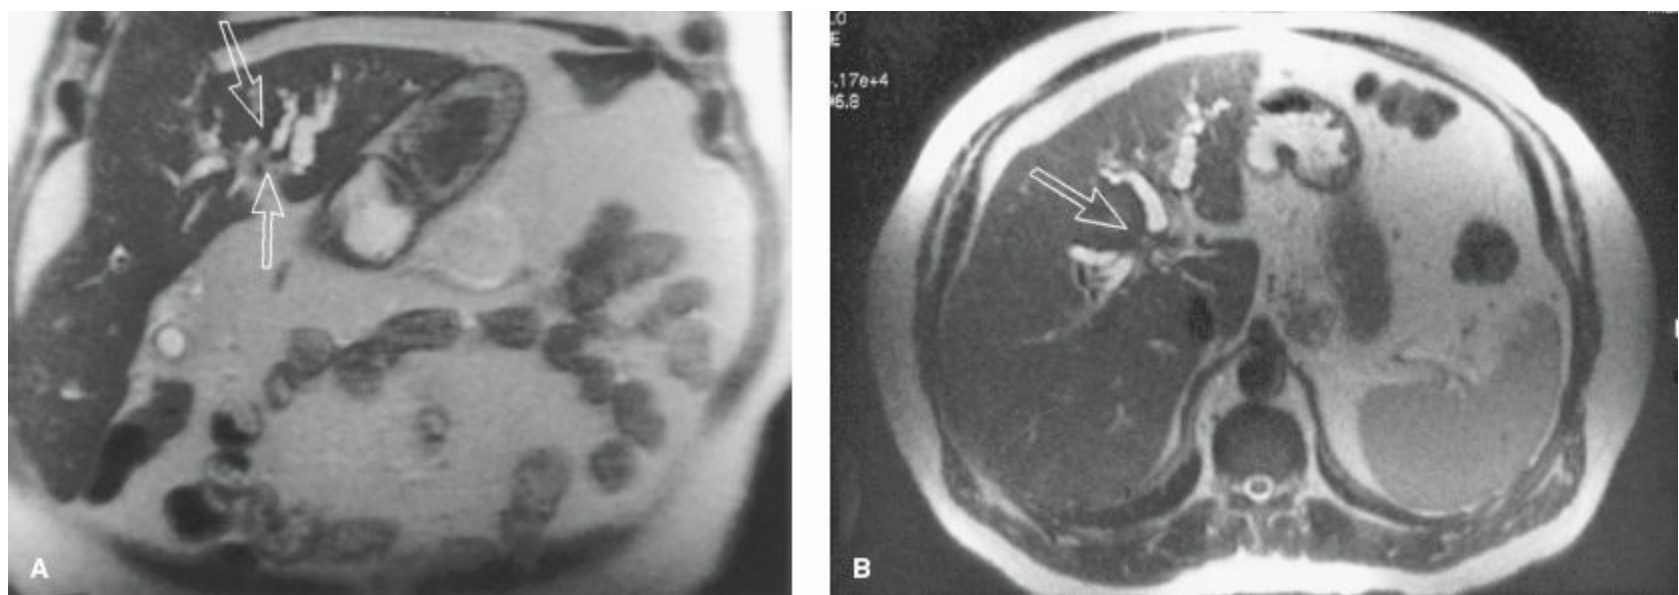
Coronal (A) and axial (B) magnetic resonance imaging in a patient with hilar cholangiocarcinoma. Dilated intrahepatic ducts are present with a soft tissue density consistent with tumor (arrows).
